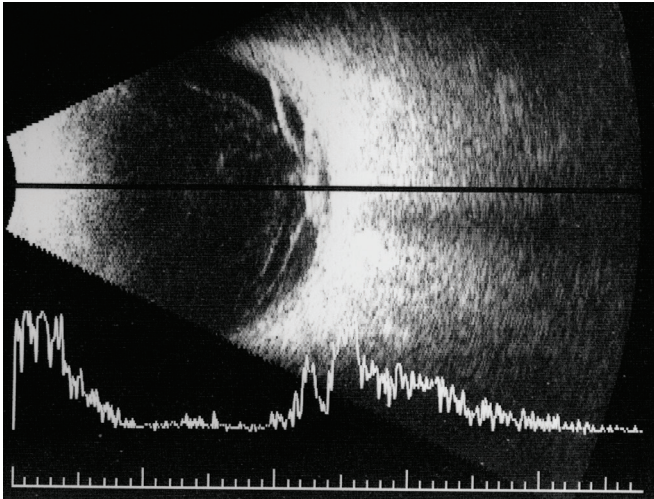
B-Scan ultrasonography shows incomplete posterior vitreous detachment and significant vitreopapillary traction. Optic nerve head is elevated approximately 2.5 mm and surrounded by localized peripapillary tractional retinal detachment.
